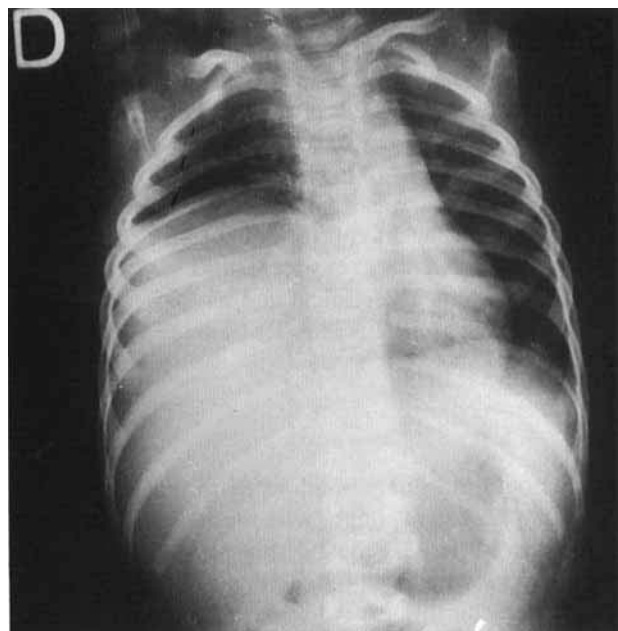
In case 2, a chest X-ray shows a density in the right lower lobe with mediastinal displacement.
